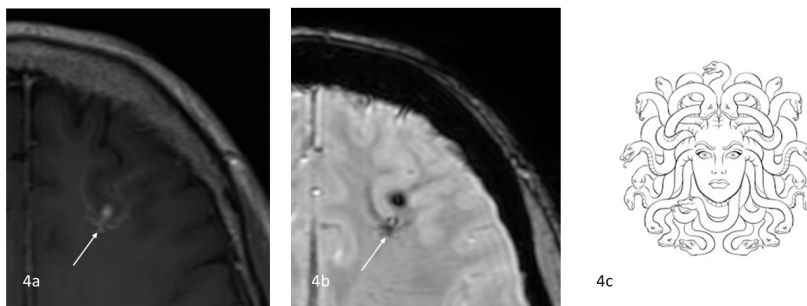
Caput medusae sign. 63 year old female with cerebral developmental venous anomaly (DVA). Axial (4a) contrast-enhanced T1-weighted and (4b) susceptibility-weighted MR images reveal a faintly enhancing lesion in the left frontal lobe with associated blooming susceptibility artefact, seemingly arranged in a radial fashion draining into a larger vein (thin white arrow). The appearance resembles Medusa's head, referred to as the "caput medusae sign", indicating a cerebral DVA. GE Medical Systems Signa Architect, 3.0 Tesla, Slice width 4.0 mm, TR 550, TE 8.19 FA 111 for T1-weighted fast spin echo (FSE) with contrast and Slice width 2.0 mm, TR 43.6, TE 24.1, FA 10 for 3D susceptibility-weighted angiography (SWAN), Intravenous contrast: 10 ml Dotarem. (4c) Caput medusa or Medusa's head (Medusa is a gorgon of Greek mythology).
